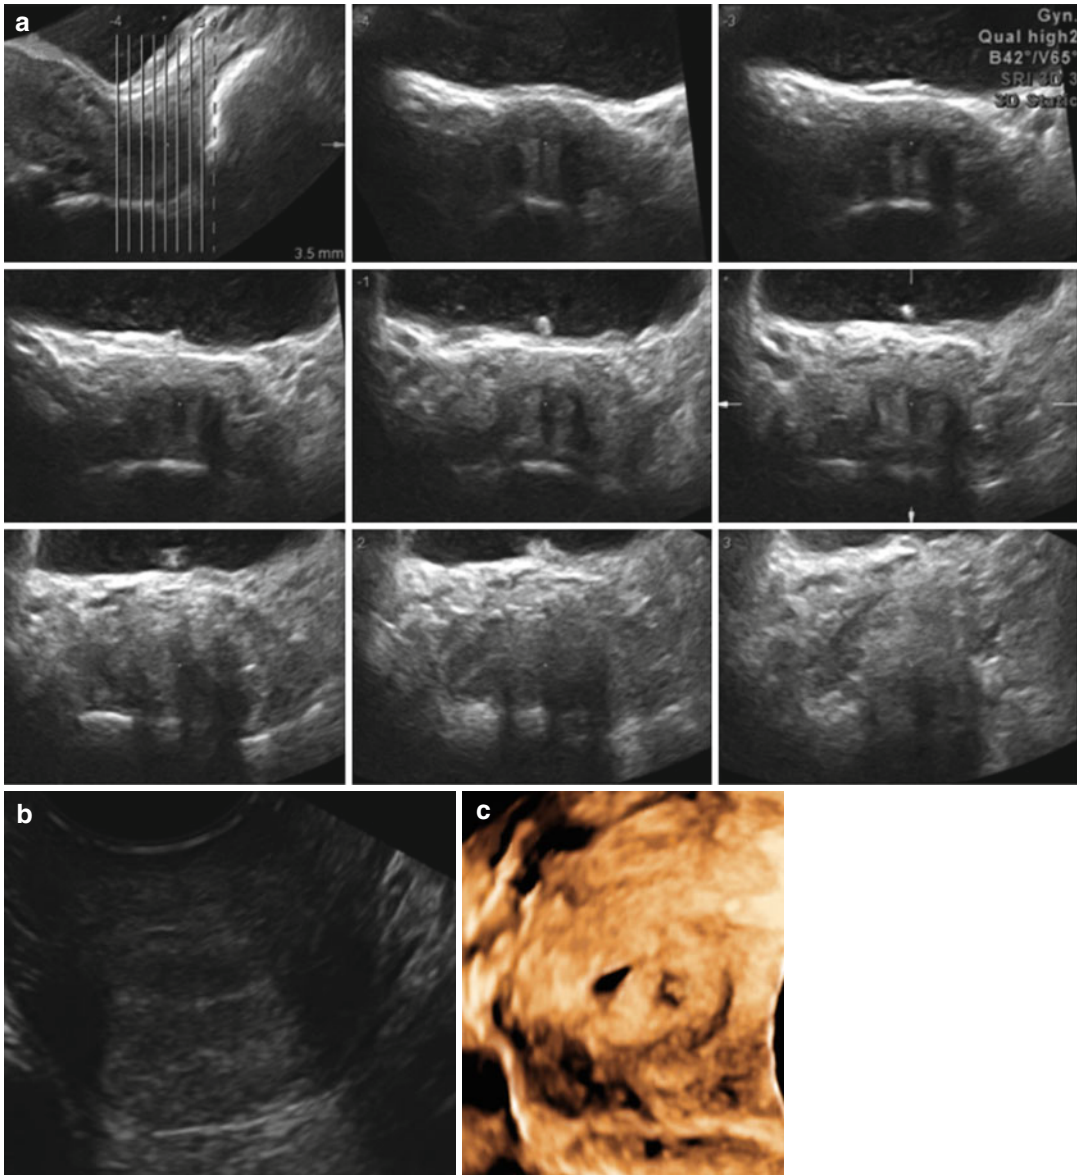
Transverse image of the cervix: (a) Transverse 2D section: ESHRE/ESGE C0, normal cervix. (b) Tomographic Ultrasound Imaging (TUI) representation of the 3D volume: ESHRE/ESGE C1, septate cervix. (c) Transverse rendered 3D image: ESHRE/ESGE C1, septate cervix
